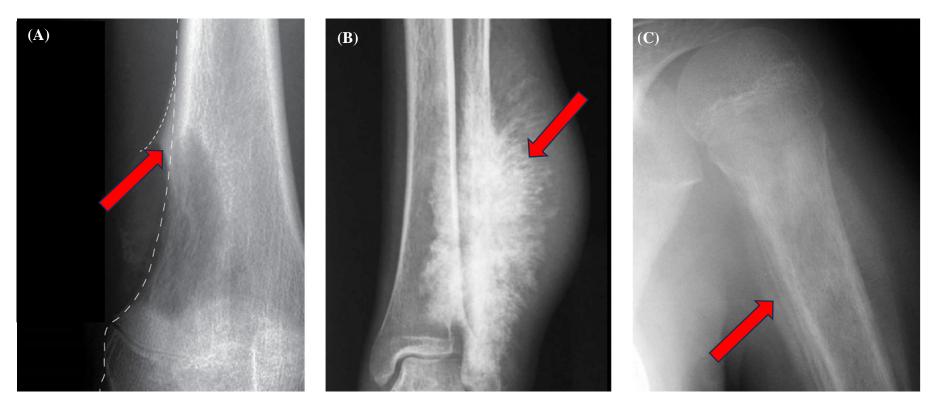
The radiograph of atypical bone features due to periosteal reaction of bone tumour. (A) Codman's triangle appearance. Adapted from *Periosteal Reaction* (2019) (B) Sunburst appearance. Adapted from *Periosteal Reaction* (2019) and (C) Onion skin appearance. Adapted from Plant & Cannon (2016). Red arrow shows the bone deformation due to tumour development.
